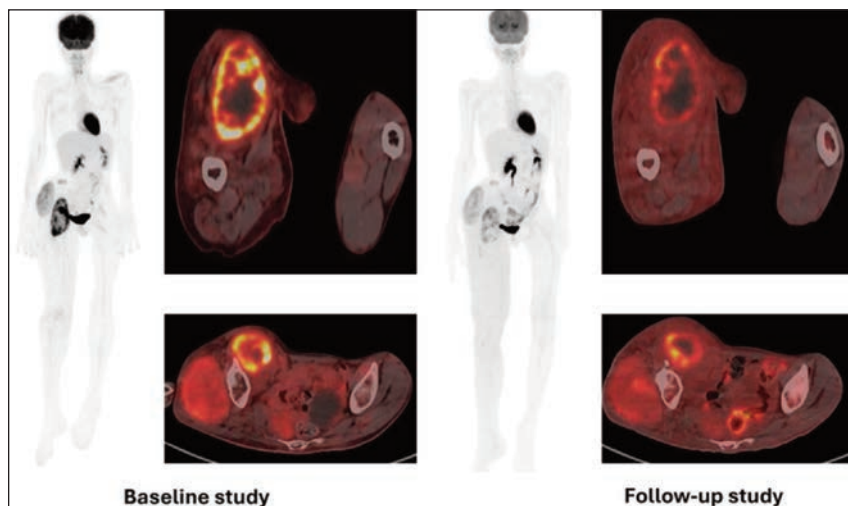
There is mild time interval reduction in size of right proximal thigh region with no significant change seen in size of right gluteal region and right pelvic region soft tissue masses suggesting stable disease, however there is significant reduction in metabolic activity in these 3 lesions (SUV max 12.4 reduce to SUV max 4.5) suggestive of partial metabolic response.
